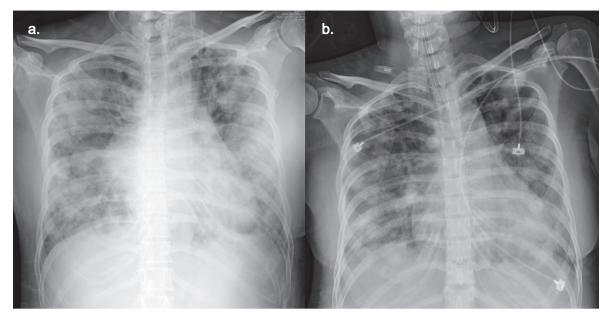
Chest radiographs during admission. a. Chest radiograph at admission revealed diffused cotton ball nodular lesions over the entire lung field bilaterally on the 1st day of admission. b. Chest radiographs showed much improvement in the bilateral lung lesions a month after chemotherapy was initiated.
